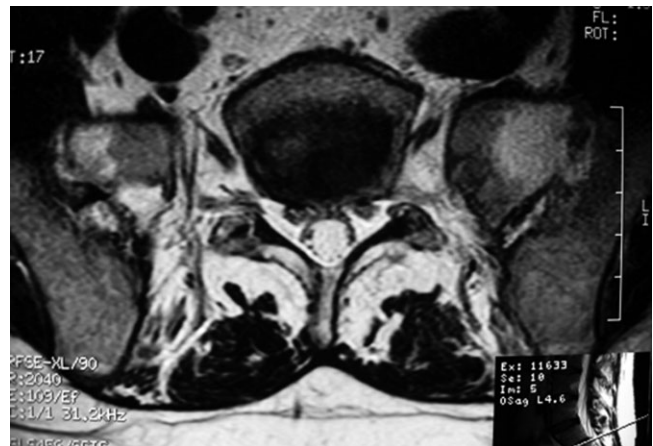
T2-weighted image showing increased intensity signals in both the sacral and iliac bones indicative of edema extending into the bone medulla.
